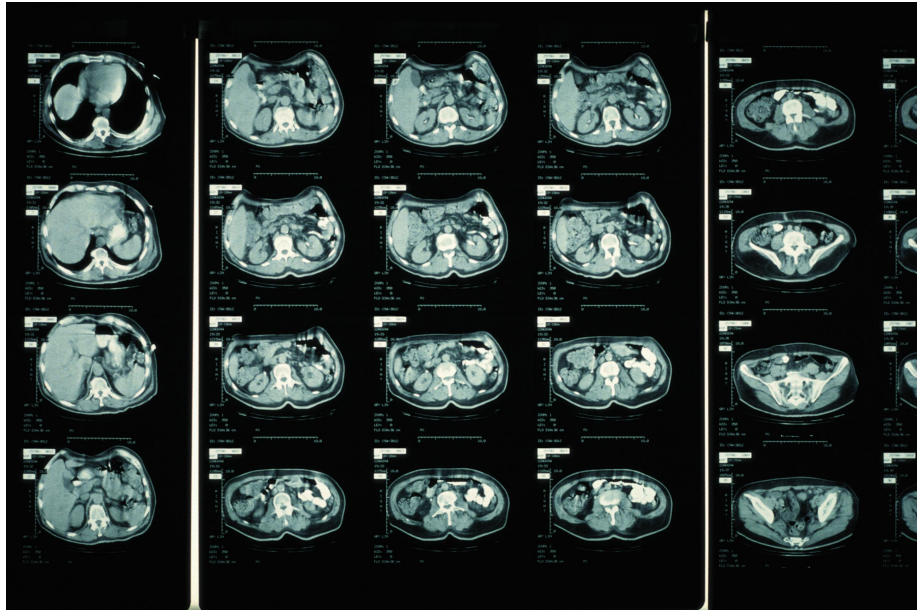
CT Scan Example with different slices representing a 3d volume
